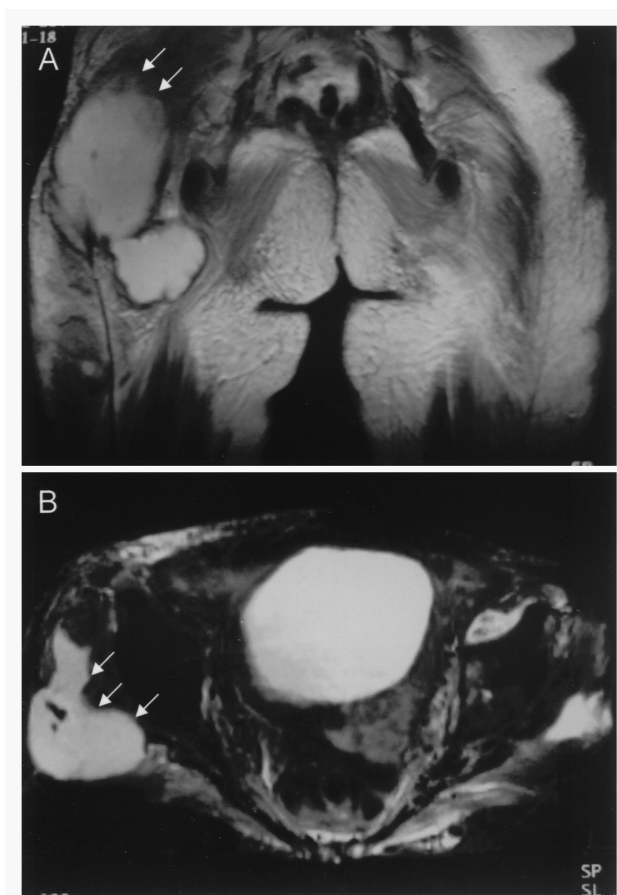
Coronal (A) and axial (B) T1- and T2-weighted magnetic resonance imaging of the pelvis showing a multiloculated abscess (arrows) in the subcutaneous area of the right buttock.
